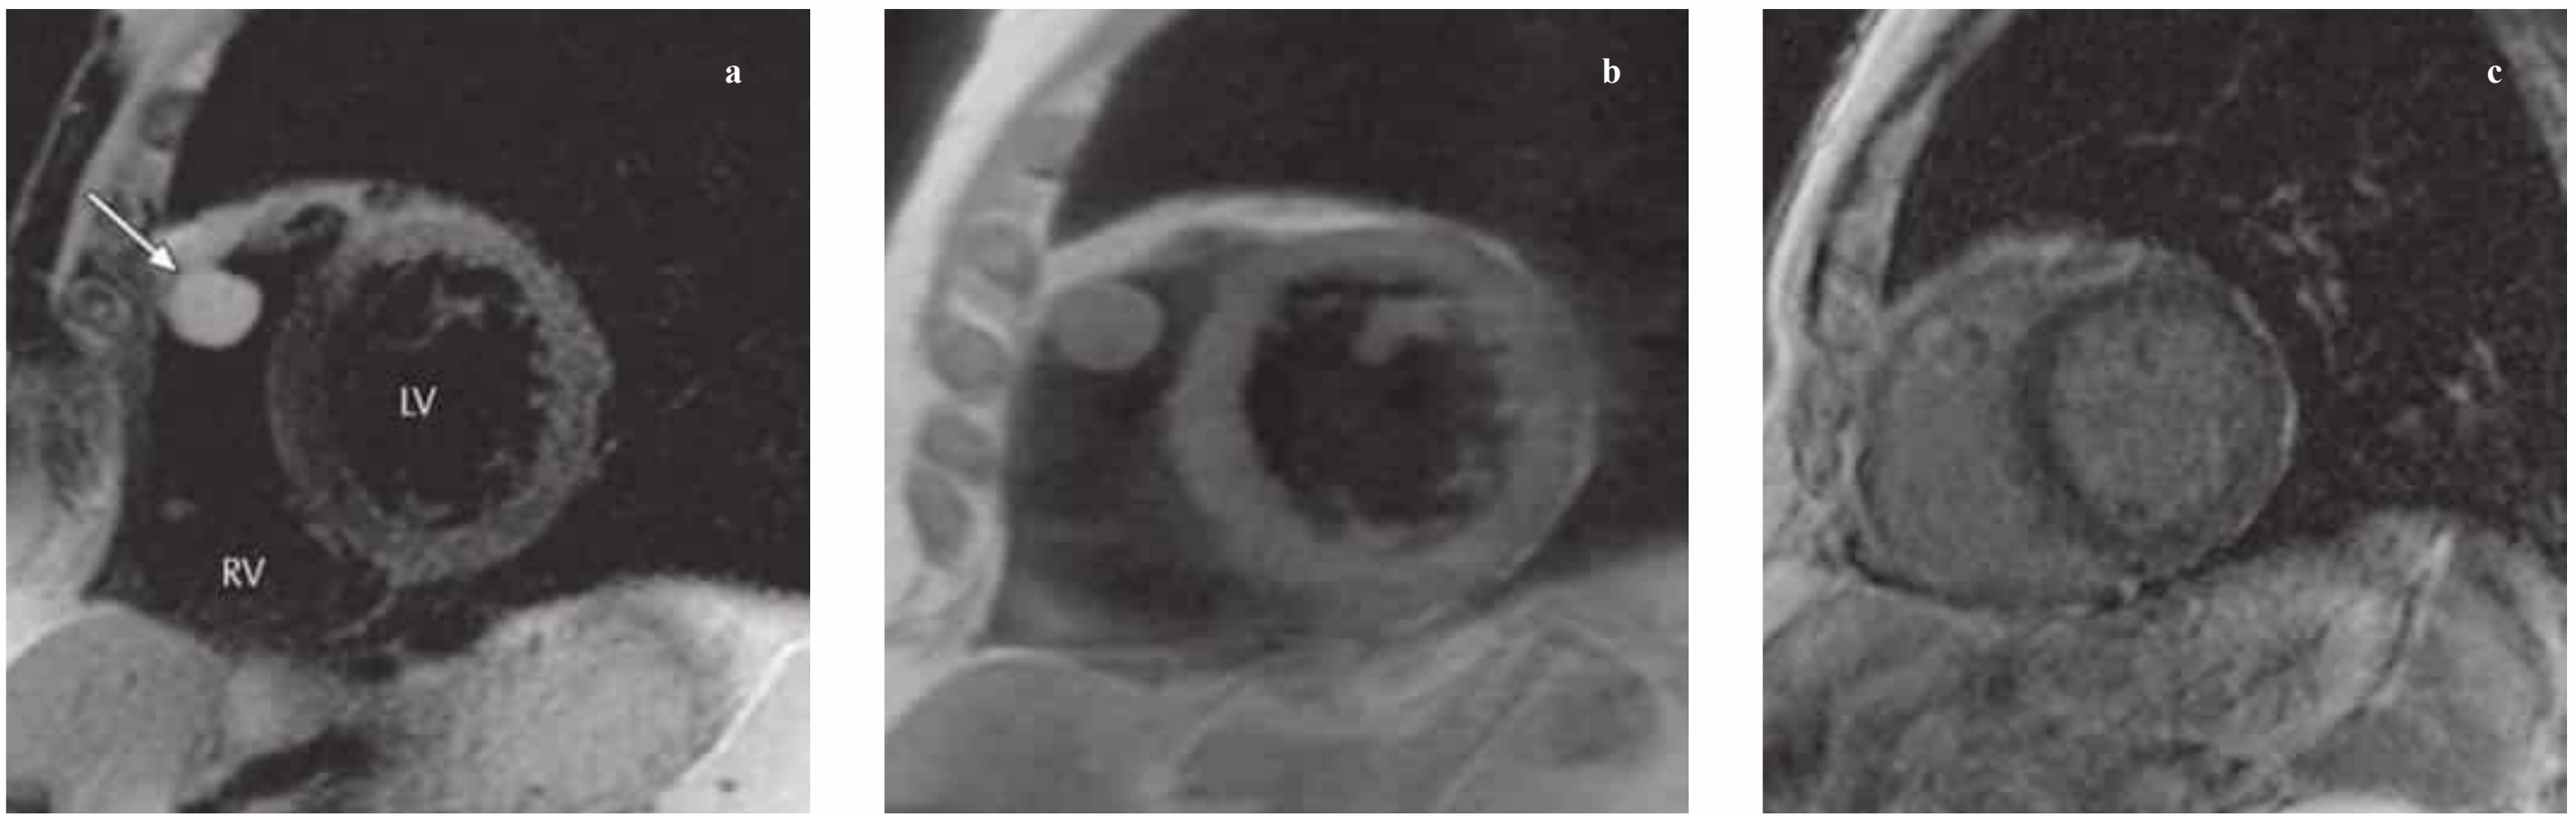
a–c Well-circumscribed hemangioma (arrow) in the right ventricular outflow tract has high signal intensity on the T2-weighted image (a) and is isointense to myocardium on the T1-weighted image (b). It shows marked contrast enhancement (c).
